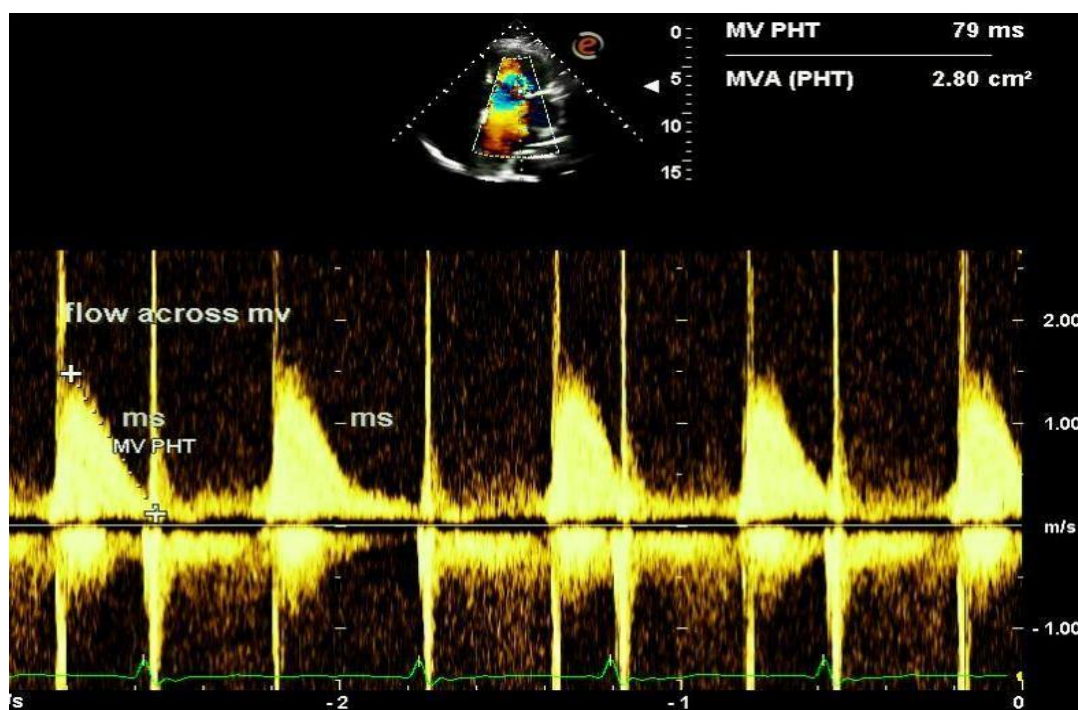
Continuous wave Doppler analysis across the mitral valve reveals mild mitral stenosis with MVA (PHT) - 2.80 sqcm with peak/ mean gradient of 12/5 mmHg.
